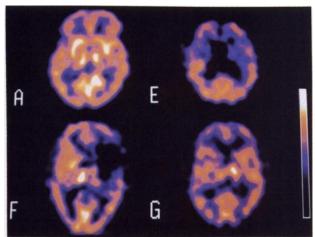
Examples of ^{99m}Tc-HMPAO SPECT perfusion patterns. Pattern A: Normal perfusion. Pattern B: Bilateral posterior temporal and parietal defects. Pattern C: Bilateral posterior temporal and parietal defects with additional frontal defects. Pattern D: Left temporal, parietal and frontal cortex defects. Pattern E: Extensive bilateral frontal defects. Pattern F: Large defect involving the right lateral frontal and anterior temporal lobes. Pattern G: Multiple small cortical defects.
